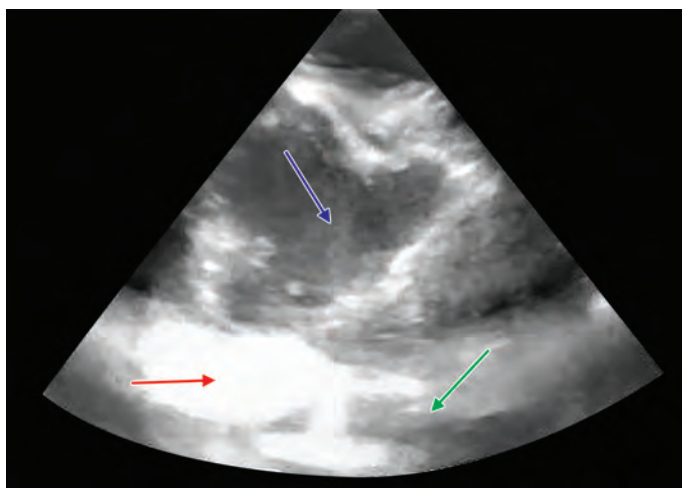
A 68-year old gentleman presented late in hospital with inferolateral wall myocardial infarction. During in-hospital stay, he developed recurrent hypotensive episodes responding to intravenous fluid, bilateral pleural effusion, and acute kidney injury. Red arrow: Left ventricle (LV) cavity in parasternal short-axis (PSAX) view. Blue arrow: Left ventricular free wall rupture (LVFWR) involving lateral wall, the ruptured site is contained by possible clot. Green arrow: Hemopericardium. This patient never had any evidence of tamponade.
